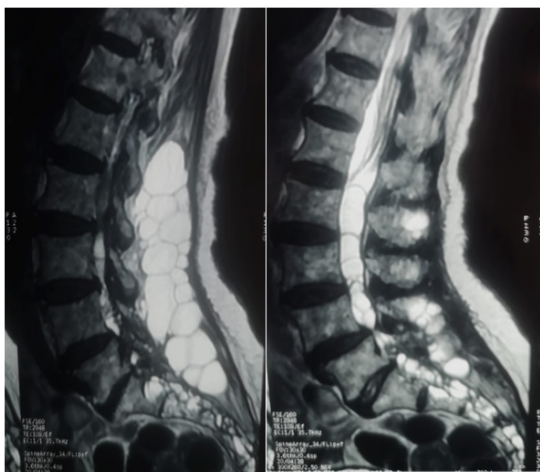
Preoperative sagittal MRI of the lumbar spinal cord
